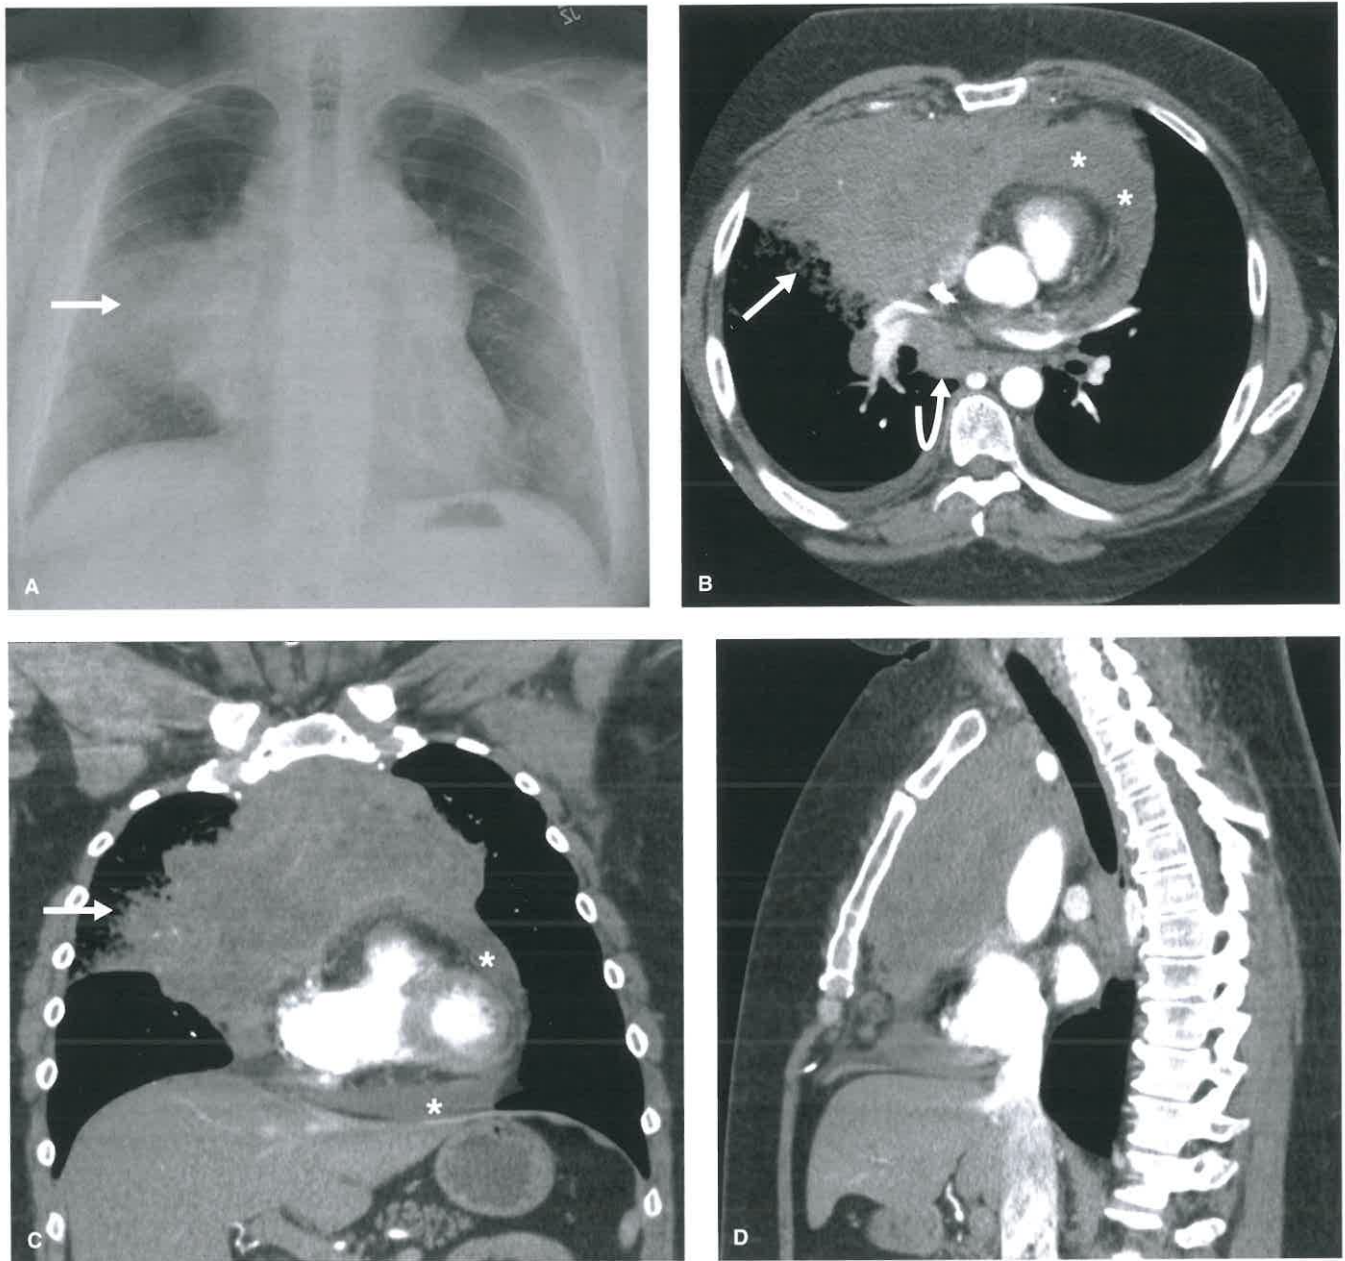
Non-Hodgkin Lymphoma, Diffuse Large B-Cell Type. A: Chest radiograph shows a mediastinal mass extending into the right perihilar lung (*arrow*). B, C, D: Axial (B), coronal (C), and sagittal (D) contrast-enhanced CT scan shows a large anterior mediastinal mass with mixed attenuation extending into the right upper lobe (*arrows* in B and C) with associated right hilar and subcarinal lymph node enlargement (*curved arrows*) small pleural effusions and a pericardial effusion (*asterisks* in B and C). Core needle biopsy showed diffuse large B-cell lymphoma.
